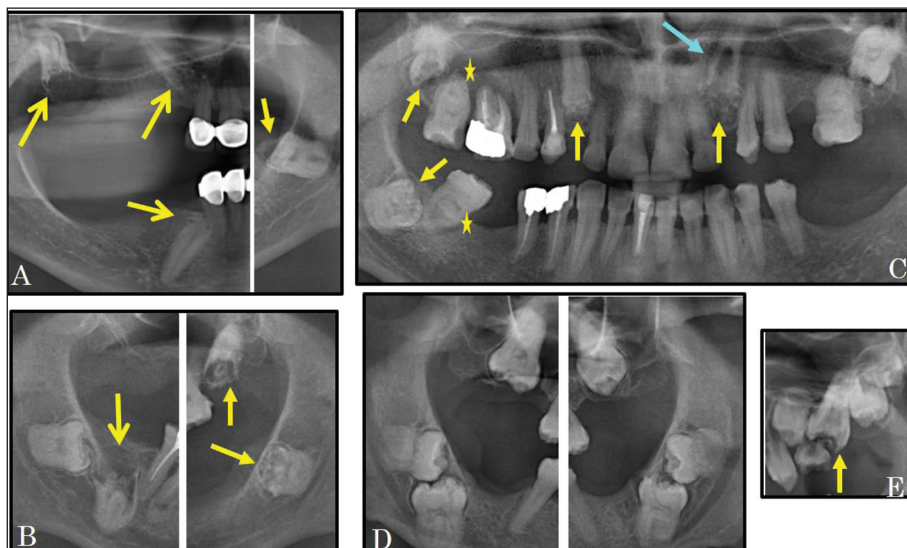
The image of cropped panoramic radiography; A: Case 2, B: Case 3, C: Case 4, D: Case 5, E: Case 6 (yellow arrow: various pre-eruptive intracoronal resorption defect, blue arrow: internal root resorption, yellow astral: dens in dent).
